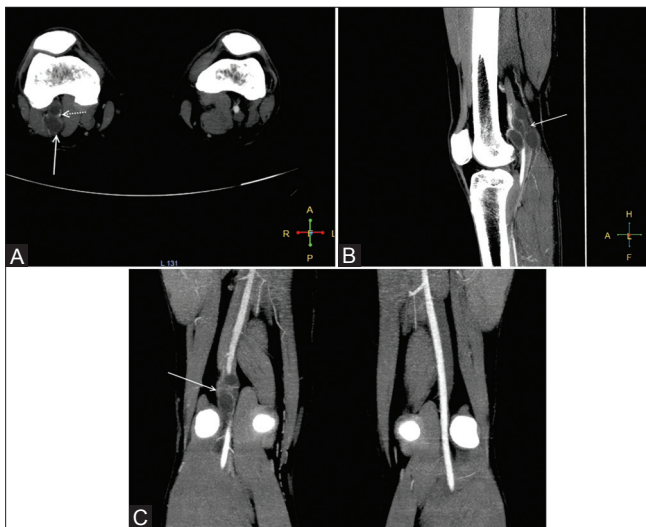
(A-C): (A) Axial, (B) Sagittal and (C) Coronal CT angiography images show multiseptated cystic lesion (white arrow) causing marked eccentric narrowing of popliteal artery (dotted white arrow in A). Contralateral normal popliteal artery is seen in C
